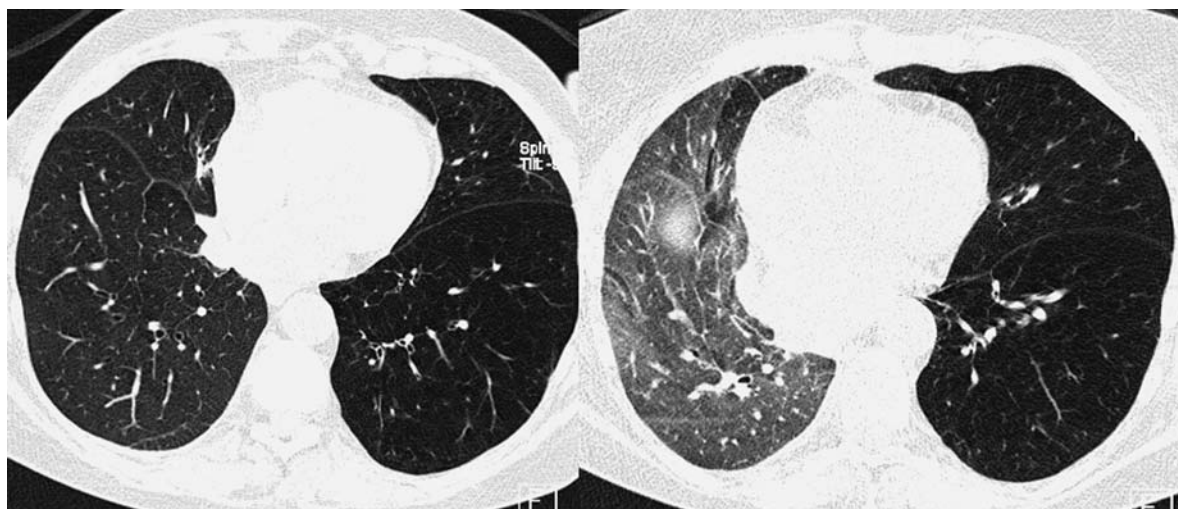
Transverse CT section after right single-lung transplantation in inspiration (*left*) and expiration (*right*). Native emphysematous lung does not change in density between inspiration and expiration, suggestive of extensive air trapping. Transplanted right lung increases in density in expiration and shows only a peripheral area of air trapping
